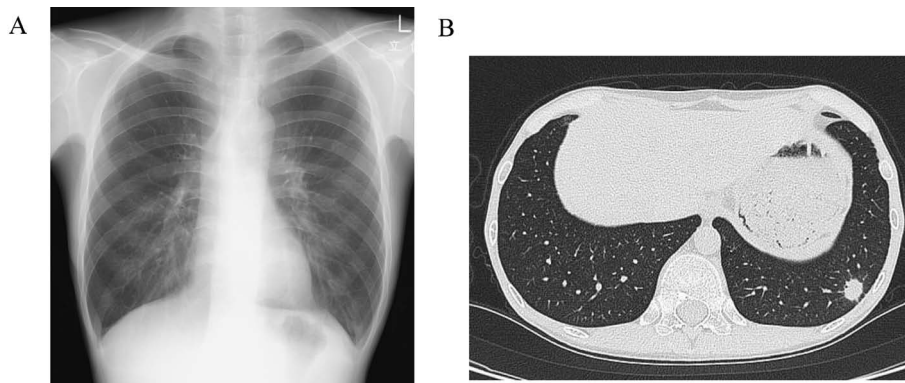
(A) Chest radiograph at the first visit. No abnormal finding was observed. (B) Chest computed tomography (CT) at the first visit. Chest CT revealed a 14-mm nodule in segment 9 of the left lung. Cavity, daughter nodule, or tree-in-bud appearance was not observed.
